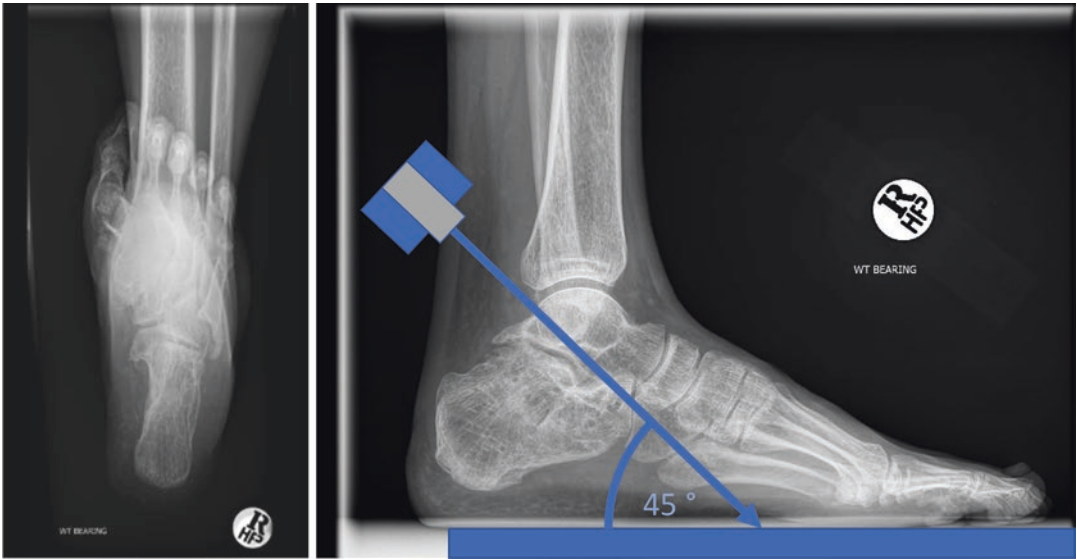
Left panel shows long axial alignment view. Right panel shows orientation of the X-ray beam and plate as described by Reilingh et al. [1]
